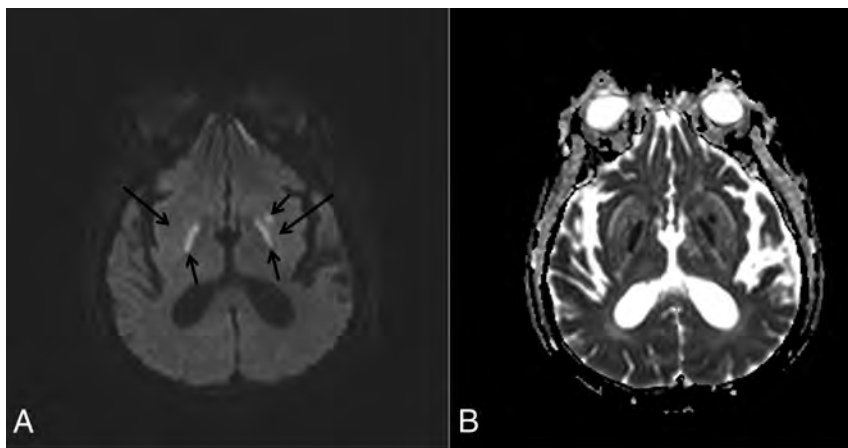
A 70-year-old man (patient 6) presented with involuntary movement. DWI (A) and an ADC map (B) show normal SI (*long arrows*) in the bilateral basal ganglia on DWI with restricted diffusion (*short arrows*) in the bilateral globus pallidus and left putamen, compatible with areas of cytotoxic edema in the lesions.
